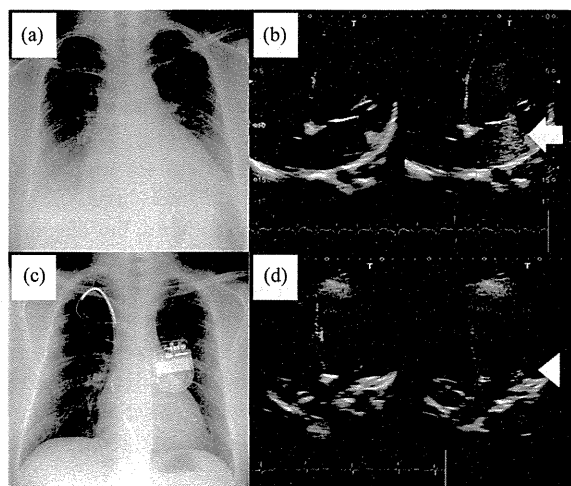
Chest X-rays and echocardiographs on admission (a, b) and at 7 months after introducing the cardiac resynchronization therapy defibrillator (CRTD) system (c, d). (a) Cardiomegaly (cardiothoracic ratio, 60%) with pulmonary congestion. (b) Apical four-chamber images of severe mitral insufficiency showing mitral annular dilatation (left panel) and severe mitral regurgitation on color flow Doppler (right panel, arrow). (c) cardiothoracic ratio of 50% with no pulmonary congestion. (d) Apical four-chamber images of mild mitral regurgitation on color flow Doppler (right panel, arrowhead) showing a marked reduction in mitral regurgitation after introducing the CRTD system and hemodialysis.
